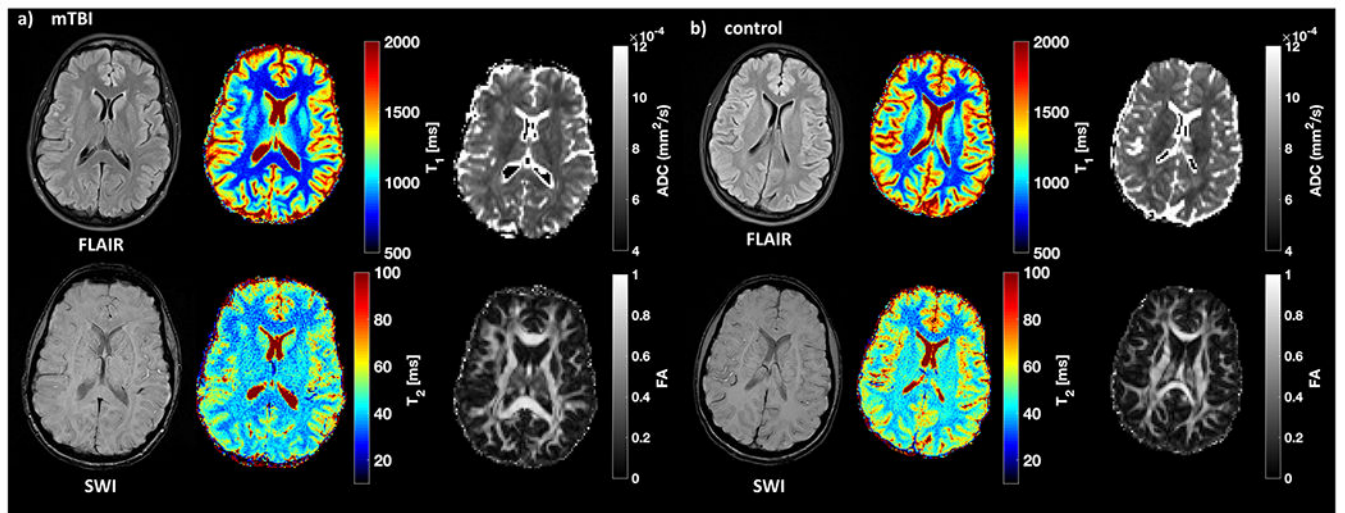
Examples of qualitative and quantitative images from a patient with mTBI and a matched control. Fluid-attenuation inversion recovery (FLAIR) and susceptibility-weighted images (SWI) as well as T₁, T₂, ADC, and FA maps from a 34-year-old female patient (a) at timepoint 1 and a 30-year-old female (b) control. Note the stark T₁ and T₂ difference between gray and white matter
